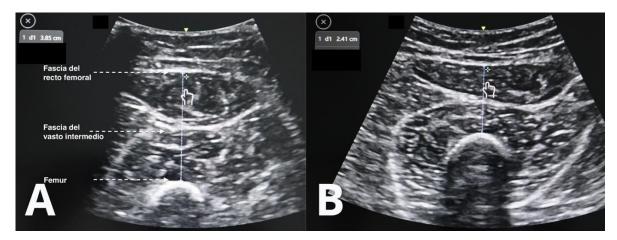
Quadriceps femoris thickness measurement. A. The ultrasound measurement is taken from the edge of the femur to the fascia of the rectus femoris, including the thickness of the vastus intermedius and rectus femoris. B. When excessive pressure is applied to the thigh, the thickness of the muscle's changes, leading to inaccurate measurements. Images A and B are from the same model, with image A showing abundant ultrasound gel and no pressure applied to the thigh (measurement: 3.8 cm), and image B showing pressure applied to the thigh (measurement: 2.4 cm).
